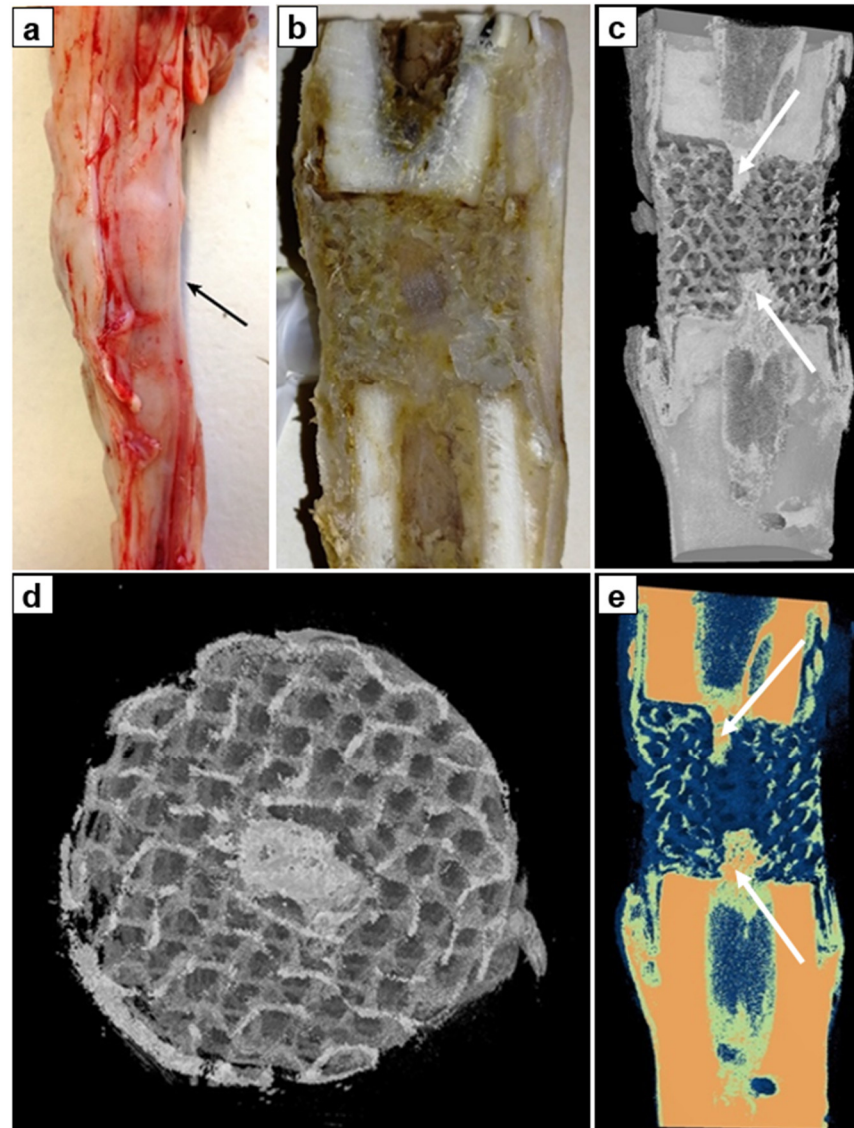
Bone-implant block after 30 days of the experiment: (a)—photo of the anatomical preparation of the tibia (the arrow indicates newly formed bone in the central canal), (b)—photo of the longitudinal section of the anatomical preparation, (c)—CT reconstruction of the anatomical preparation in the range of the shades of gray ($\times 1.1$), (d)—CT image of a cross-sectioned anatomical preparation in the range of the shades of gray ($\times 2.8$), (e)—colored visualization of a cross-sectioned anatomical preparation using the Smart colors filter ($\times 1.1$).
